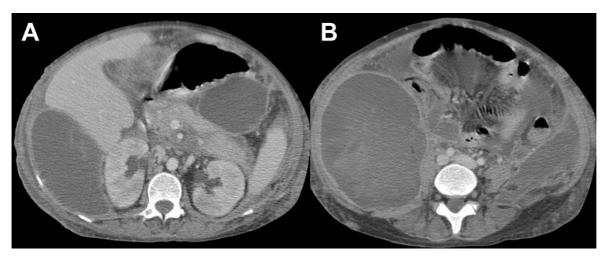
Contrast-enhanced CT scans in a 24-year-old female had acute pancreatitis (grade E): (A) and (B) CT scans show multiple fluid collections, the largest one with high density content locates at right subhepatic space and right paracolic gutter
